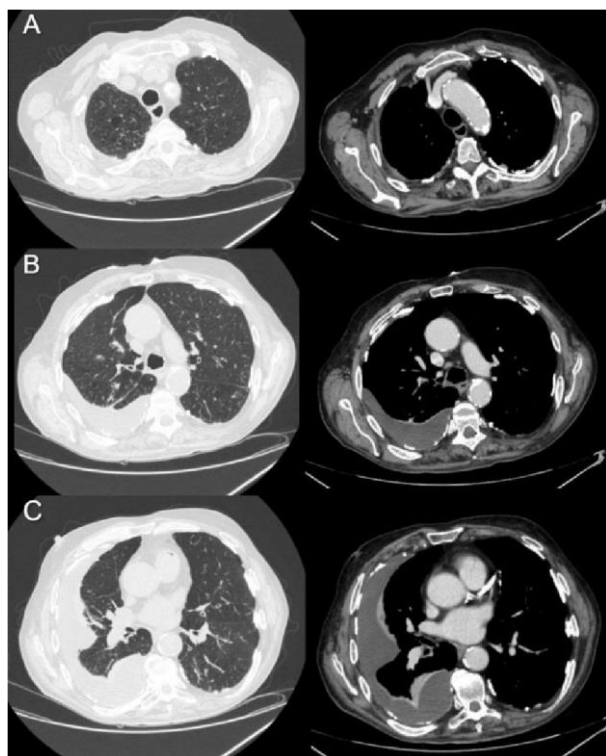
Chest-CT-scan with comparative lung and mediastinal window. Pleural effusion mainly on the right and diffuse pachypleuritis. A) Upper lung field B) Middle lung field C) Lower lung field.
